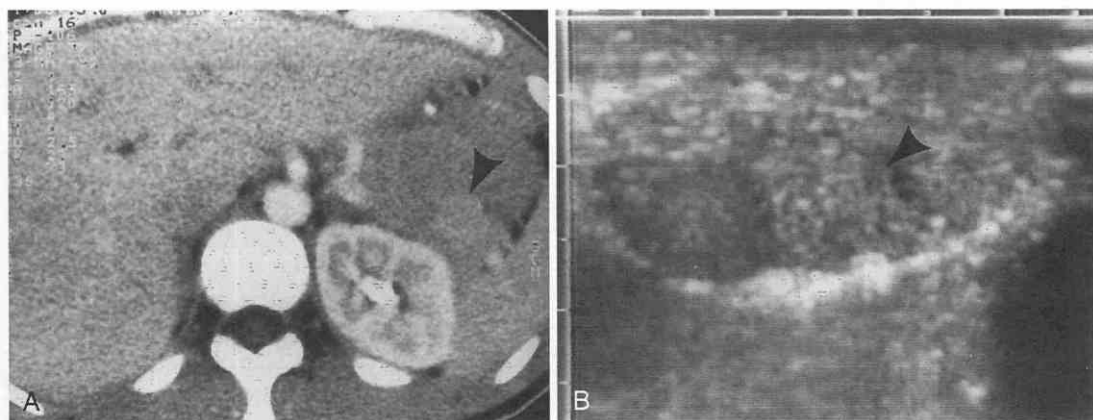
A, CT scan with intense contrast enhancement shows considerable enhancement of small pancreatic insulinoma. B, Intraoperative ultrasound scan shows small echogenic mass with hypoechoic "halo" (arrowhead). This procedure still has the highest detection rate, but MRI can provide accurate preoperative diagnosis.
